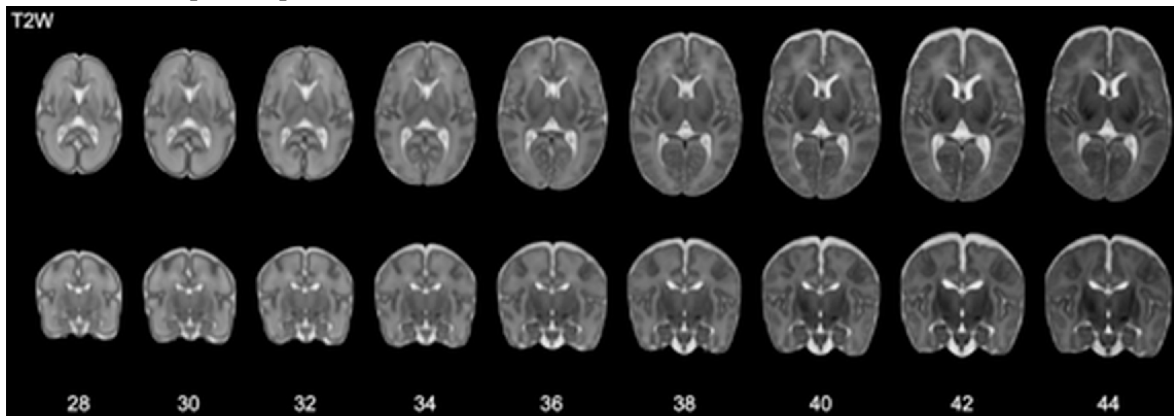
Growth and development of the preterm human brain with MRI images. Axial (top row) and coronal (bottom row), with the postmenstrual age (in weeks). [12]
